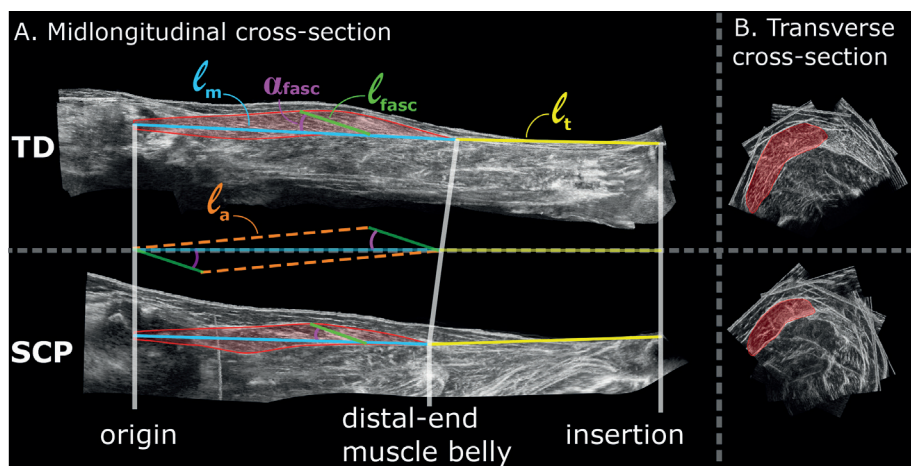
Examples of lower leg 3D ultrasound images from TD (top) and SCP (bottom) children.
